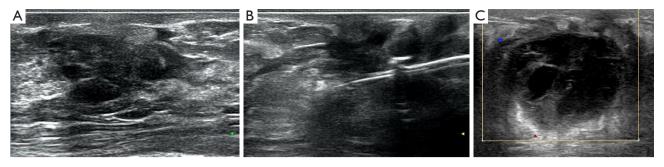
US-VAE for benign breast lesions larger than 3 cm. (A) A 36-year-old female with fibroadenoma of right breast. Ultrasonography shows a regular distinct and hypoechoic lesion in the right breast with a maximum size larger than 3 cm; (B) ultrasonography shows the incision needle in the lesion; (C) hematoma at the incision site after VAE. US-VAE, ultrasound-guided vacuum-assisted excision; VAE, vacuum-assisted excision. (Green and yellow arrowheads indicate the focal position of ultrasound imaging).
